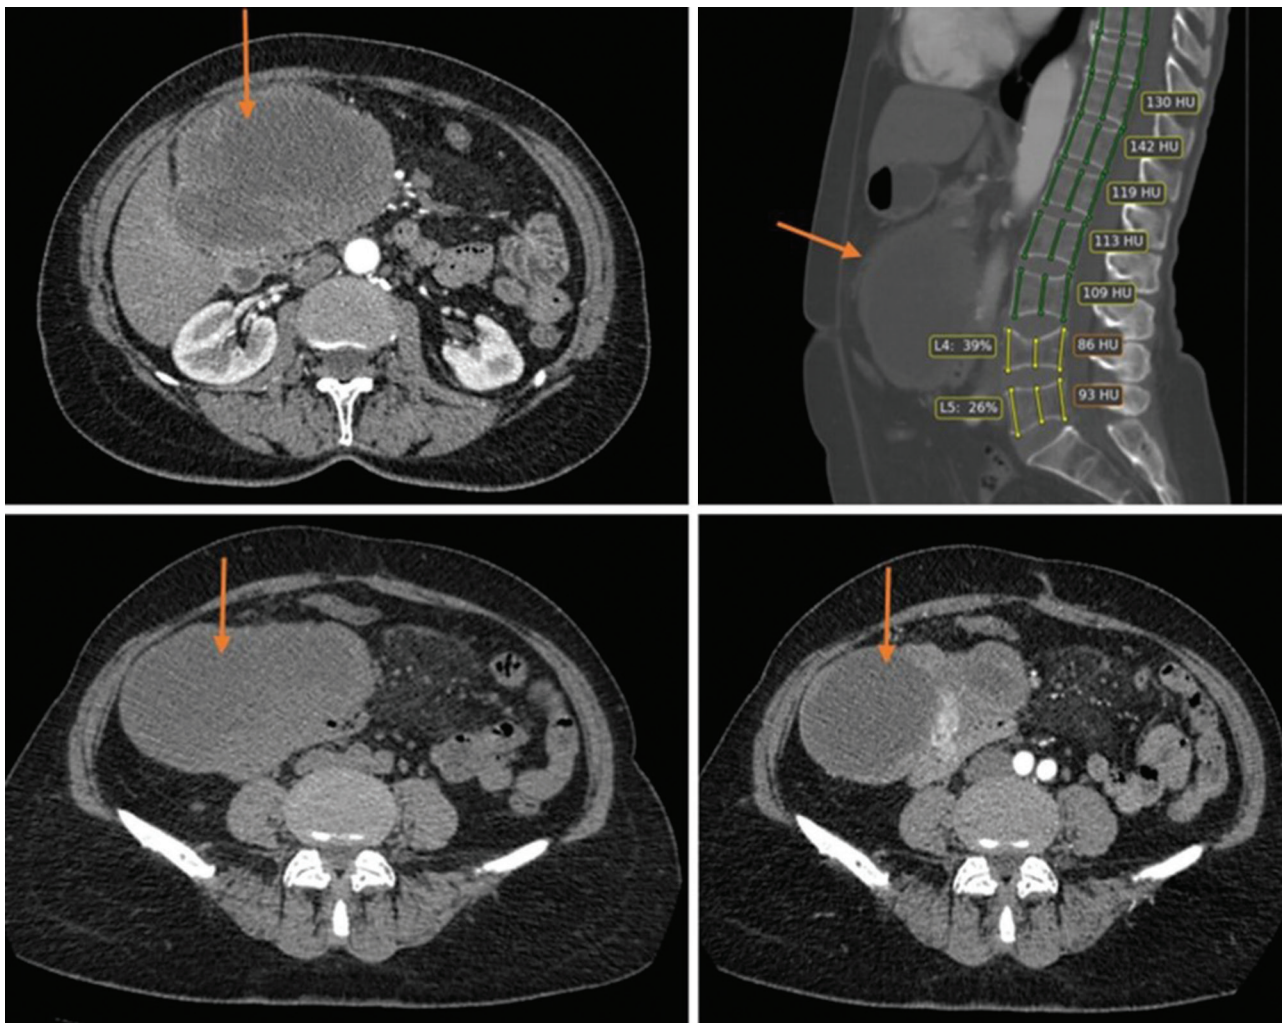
CT image of the mass formation of the abdominal cavity.
